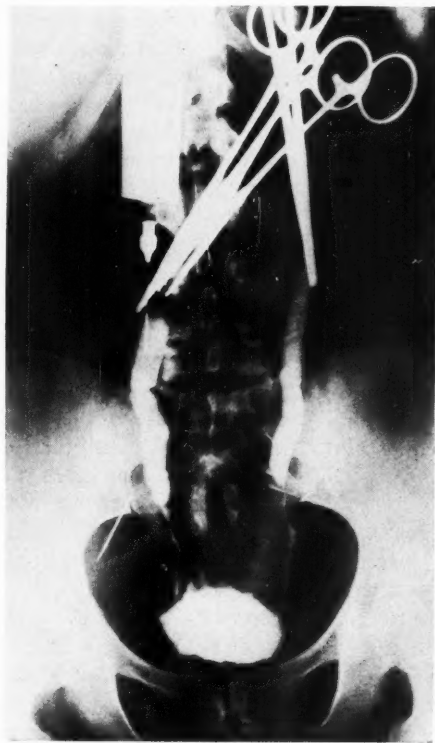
Roentgenogram made postmortem after injection of sodium iodide into proximal ureters. The straight pins are placed along the iliac vessels. The lower three inches of the ureters are narrowed and displaced somewhat medially. The proximal ureters are dilated.
